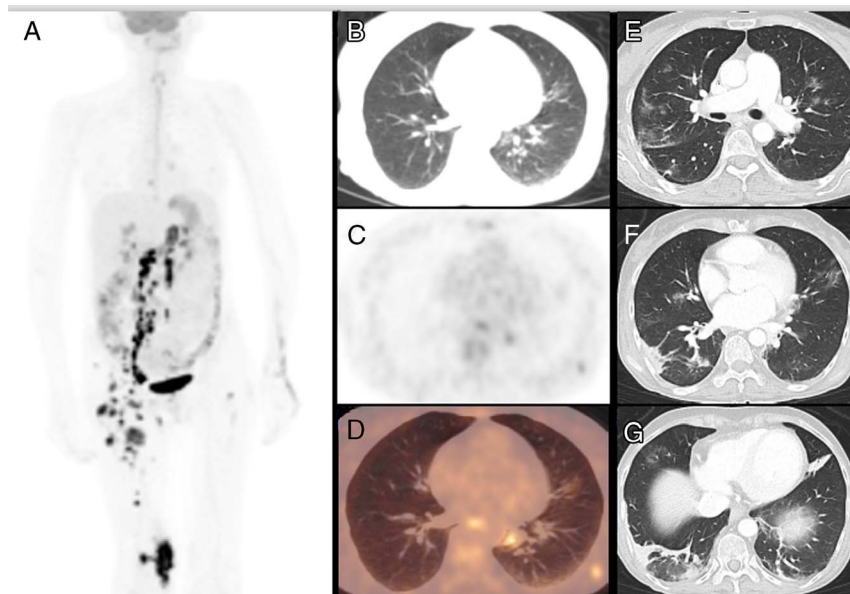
A 47-year-old woman affected by an advanced stage anaplastic large-cell lymphoma relapsed after 2 chemotherapy regimen lines and was hospitalized for starting new chemotherapy cycle. Before starting, she did a nasopharyngeal swap with RT-PCR positive for COVID-19. ^{18}F -FDG PET/CT confirmed the metabolic progression of disease with nodal, muscular, and skeletal hypermetabolic localizations (A). A moderate FDG uptake (SUV_{max} 5.6) was showed in small GGOs, especially in the left inferior lobe (B–D). A subsequent chest CT demonstrated a progression of interstitial pneumonia with massive lung involvement (E–G).
